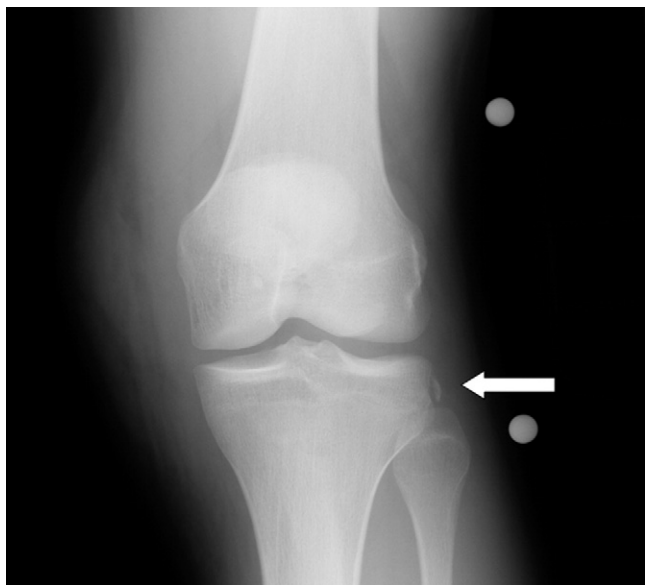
Radiograph of the knee demonstrating a small vertical avulsion injury of the lateral aspect of the proximal tibia immediately distal to the tibial plateau.
